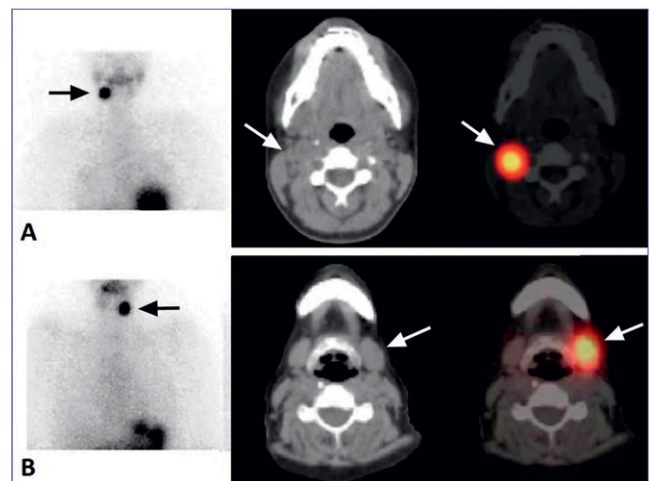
(A) Patient with papillary thyroid cancer (PTC) status postthyroidectomy underwent diagnostic ^{131}I SPECT/CT. Focal uptake in right submandibular region on planar images was suspicious for nodal disease (arrow). SPECT/CT showed an enlarged right cervical level II lymph node with focal ^{131}I uptake (arrows). (B) Another patient with PTC treated with thyroidectomy and ^{131}I for thyroid remnant ablation returned for surveillance imaging 1 y after surgery. Planar images showed focal uptake in left submandibular region (arrow). SPECT/CT localized focal uptake to normal left submandibular gland, representing asymmetric physiologic uptake (arrows).
